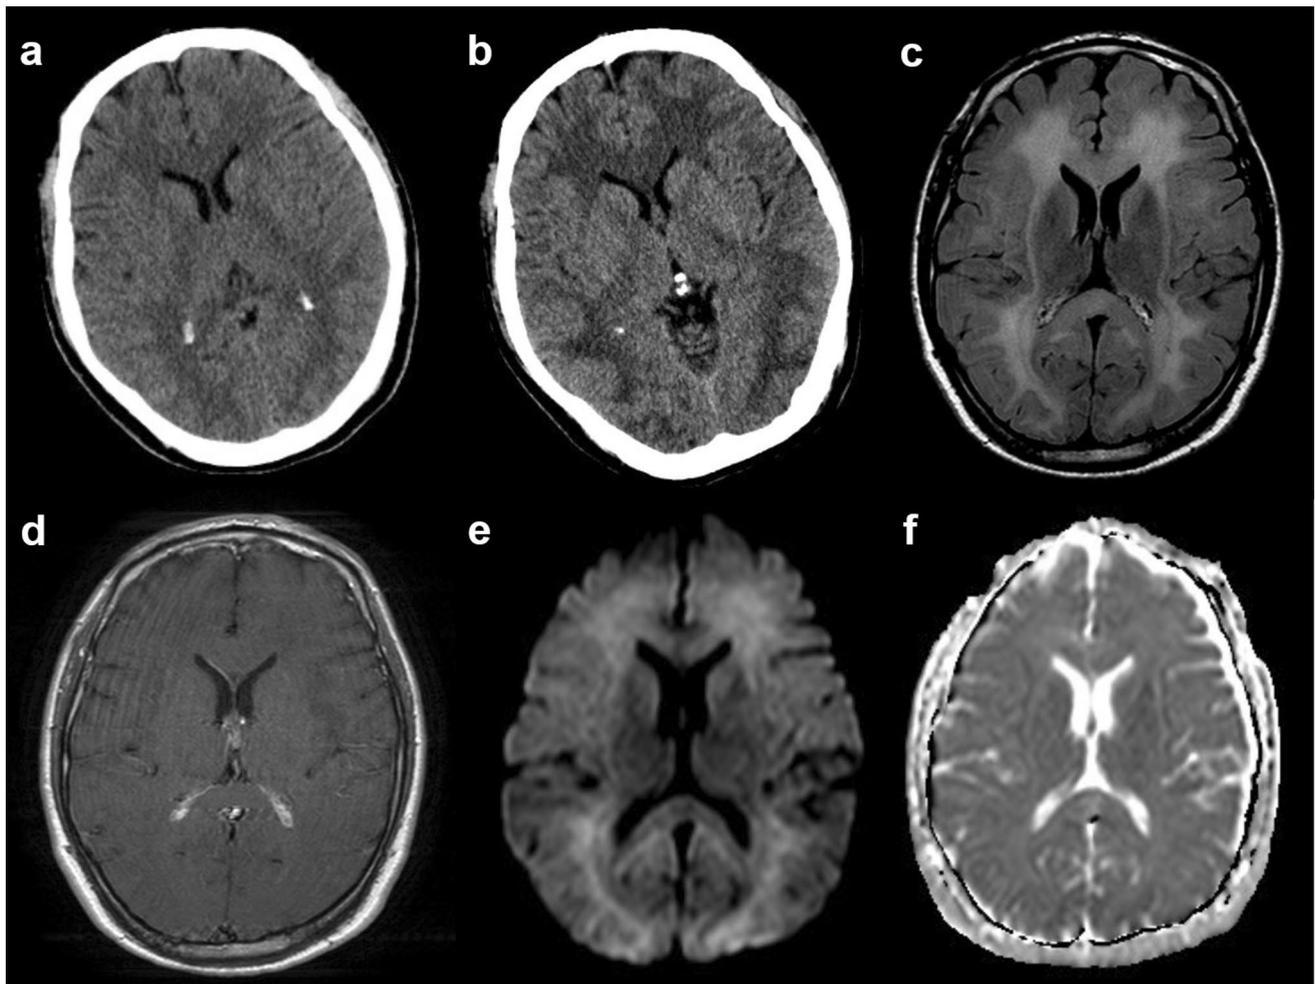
Compared to the first brain CT images (a), the subsequent follow-up brain CT 1 month later (b) showed more pronounced white matter hypointensities. The diffuse white matter abnormality was distributed in the centrum semiovale and periventricular regions with extension to the subcortical U fibers and corpus callosum but did not involve the cortex or deep gray matter structures (c axial FLAIR
